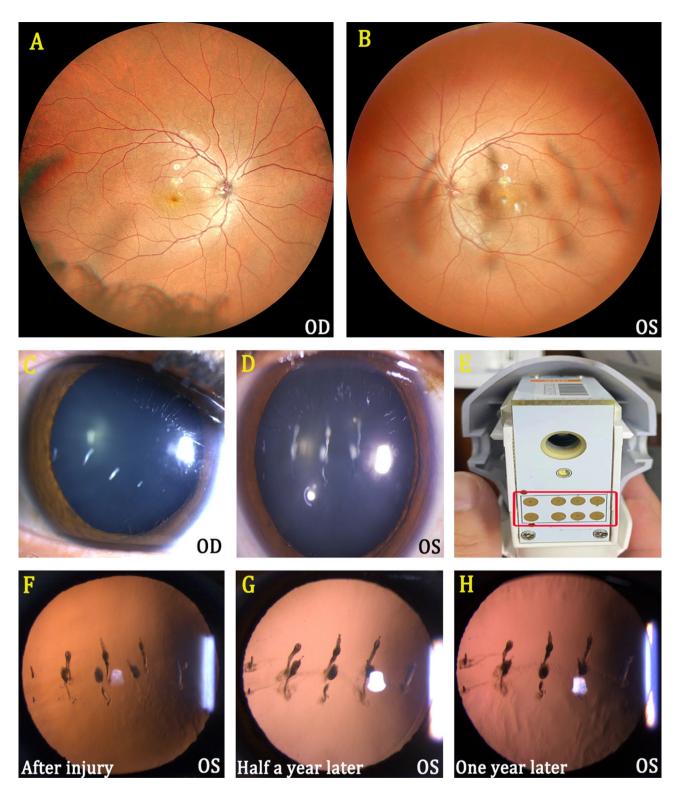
Lens opacification induced by HIFU. (A,B) Bilateral fundus photography. (C,D) Bilateral lens opacity (E) Ultrasound probe. Red box: ultrasonic energy excitation point. (F, G,H)Lens opacity diffusion
